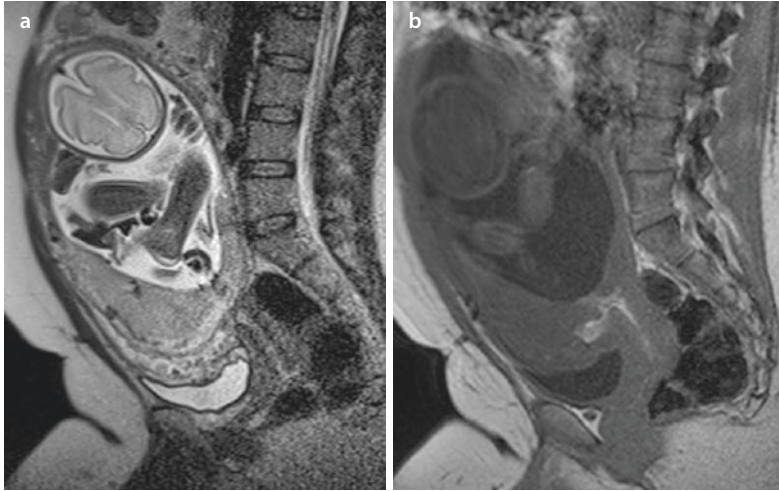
a, b Placenta praevia. T2-weighted sequence sagittal a with displacement of the placenta in front of the cervix. The basal decidua to
